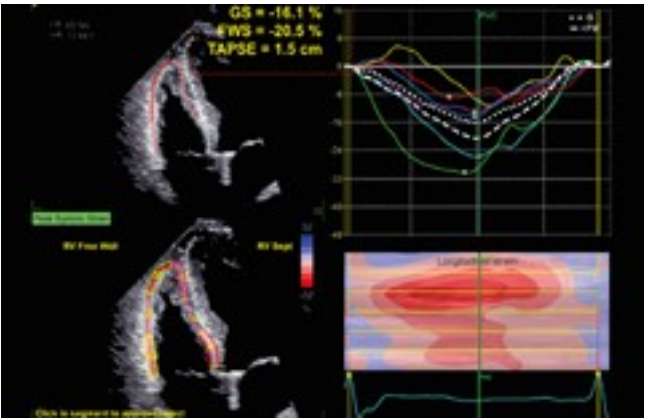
Measurements of RV global strain (RVGS) and free wall strain (RVFWS) using two-dimensional speckle-tracking echocardiography
